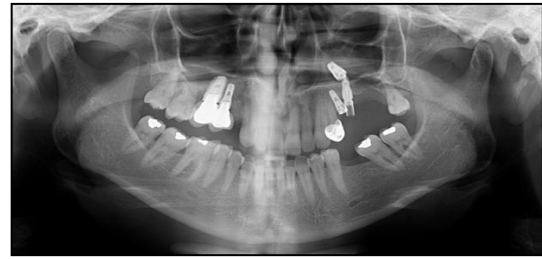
An orthopantomograph showing a case of failed implant supported restoration with one implant displaced into left maxillary sinus.
